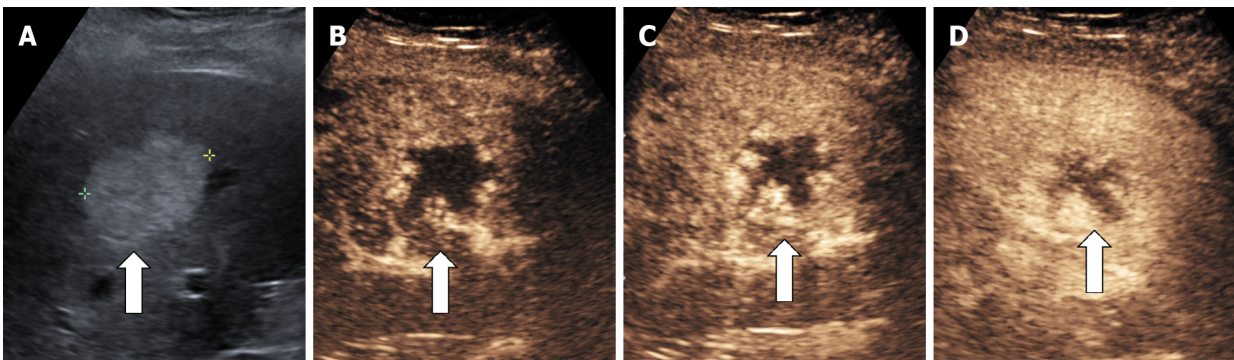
Typical hepatic hemangioma in B-mode ultrasound. A: Hyperechoic mass with sharp margins; B-D: After contrast agent administration the mass shows peripheral nodular enhancement in arterial phase (B and C) with partial centripetal filling in the late phase (D).
